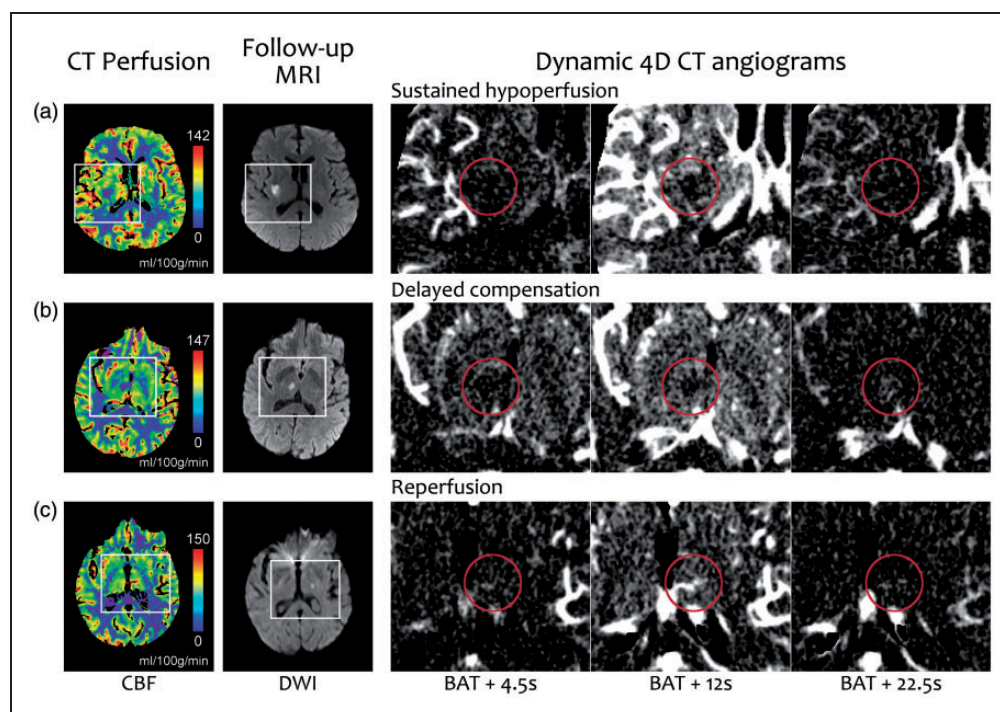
Representative examples of each of the three commonest perfusion patterns on dynamic 4D CT angiograms (D4DCTA). The first and second columns show the CBF map and DWI, with white rectangles marking the areas enlarged in the next three columns that show frames of the D4DCTA with different times from the bolus arrival time (BAT). The red circle indicates the ROI of the ischemic lesion. (a) There is no contrast filling the ROI in any frame, which is consistent with a sustained hypoperfusion. The signal in the ROI in the third frame is not higher than in the surrounding parenchyma. (b) There is a late contrast filling visible in the third frame, indicating a delayed compensation. (c) An early antegrade contrast filling is visible in the first frame, consistent with reperfusion. For a better understanding of these patterns, see the Supplemental video online.
